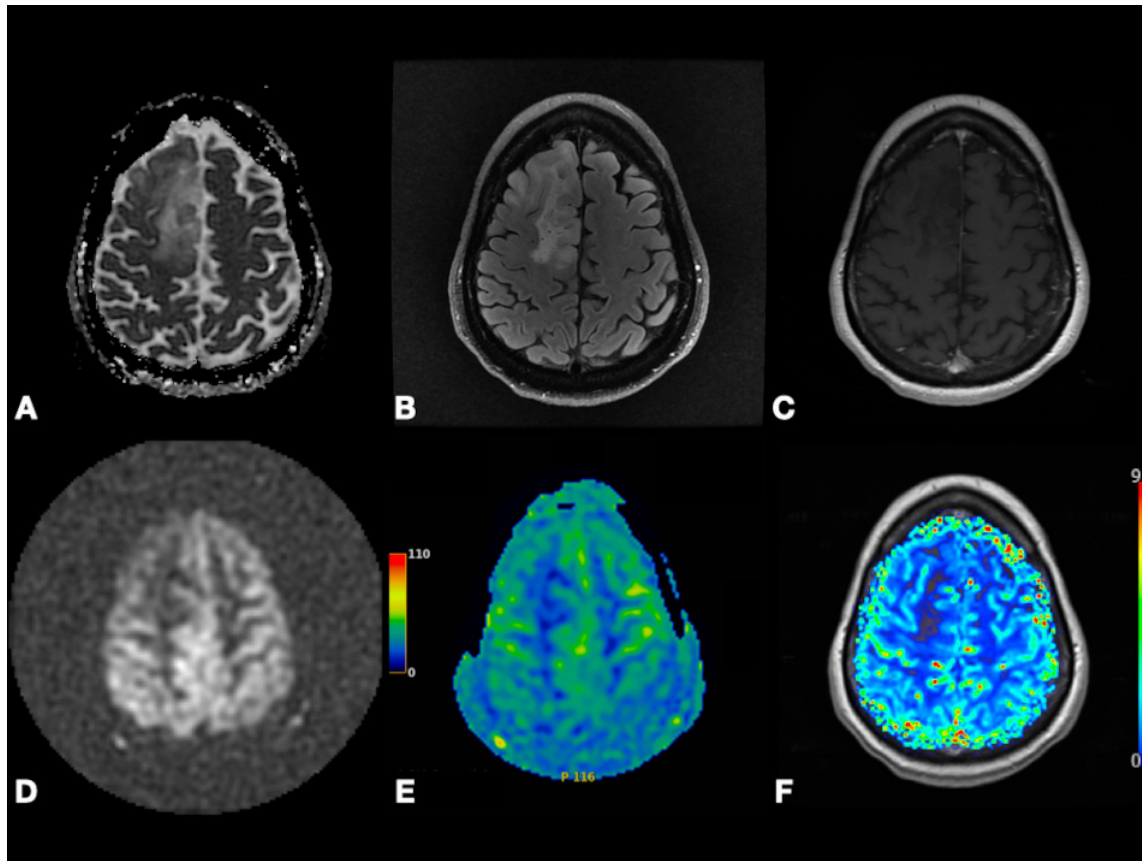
Right frontal lobe oligodendroglioma (WHO Grade 2). Axial ADC map (A), FLAIR (B), and post-contrast T1-weighted (C) images depicting non-enhancing tumor with T2 prolongation in gray and white matter and increased diffusivity (i.e., shine-through artifact). Axial pcASL source data (D), color-coded CBF map (E) from pcASL data, and color-coded rCBV map (F) from DSC data depicting no hyperperfusion. Abbreviation: ADC, Apparent diffusion coefficient; FLAIR, Fluid attenuated inversion recovery; pcASL, Pseudo-Continuous Arterial Spin Labeling; CBF, cerebral blood flow; rCBV, relative cerebral blood volume; DSC, Dynamic susceptibility contrast MR imaging.
